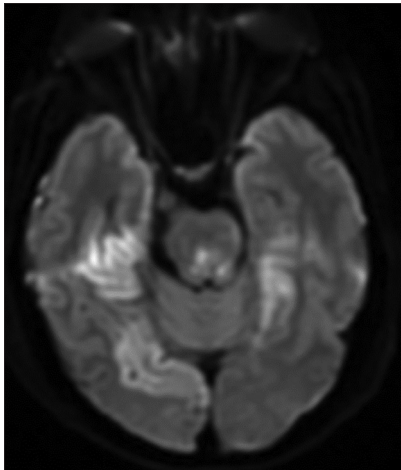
Diffusion weighted magnetic resonance imaging brain imaging showing restricted diffusion in B/L posterior cerebral artery territory
